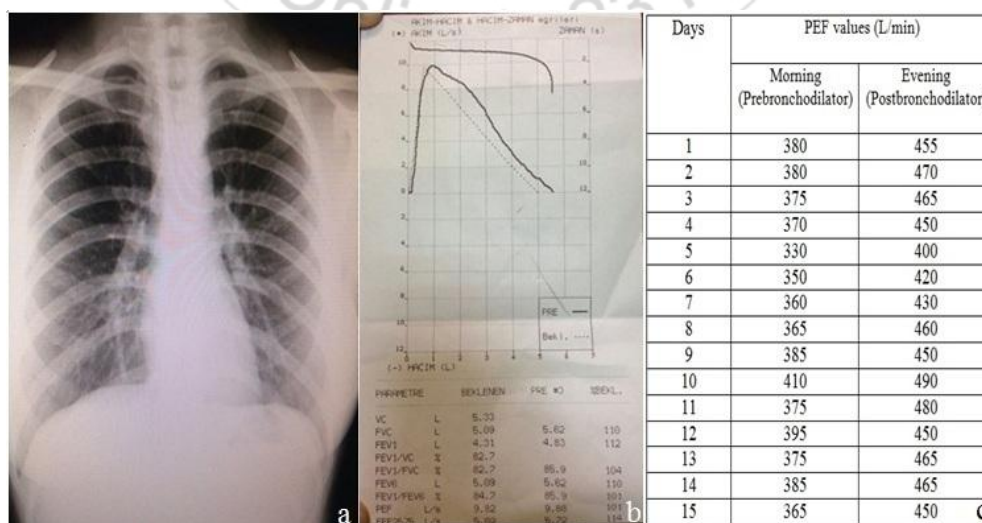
(a) Posteroanterior chest radiograph of the patient on admission. (b) Spirometry of the patient. (c) PEF levels of the patient
